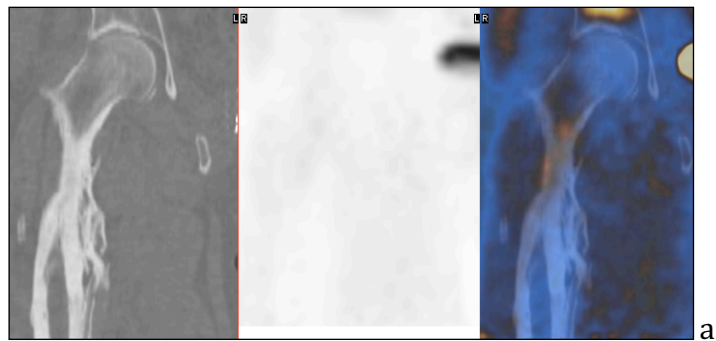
Multiplanar ^{18}F -FECH PET/CT with coronal, axial, and MIP (maximum intensity projection) images showing sclerosis, periosteal thickening, and low-grade uptake at the proximal aspect of the right femur. This patient had a previous history of osteomyelitis.
